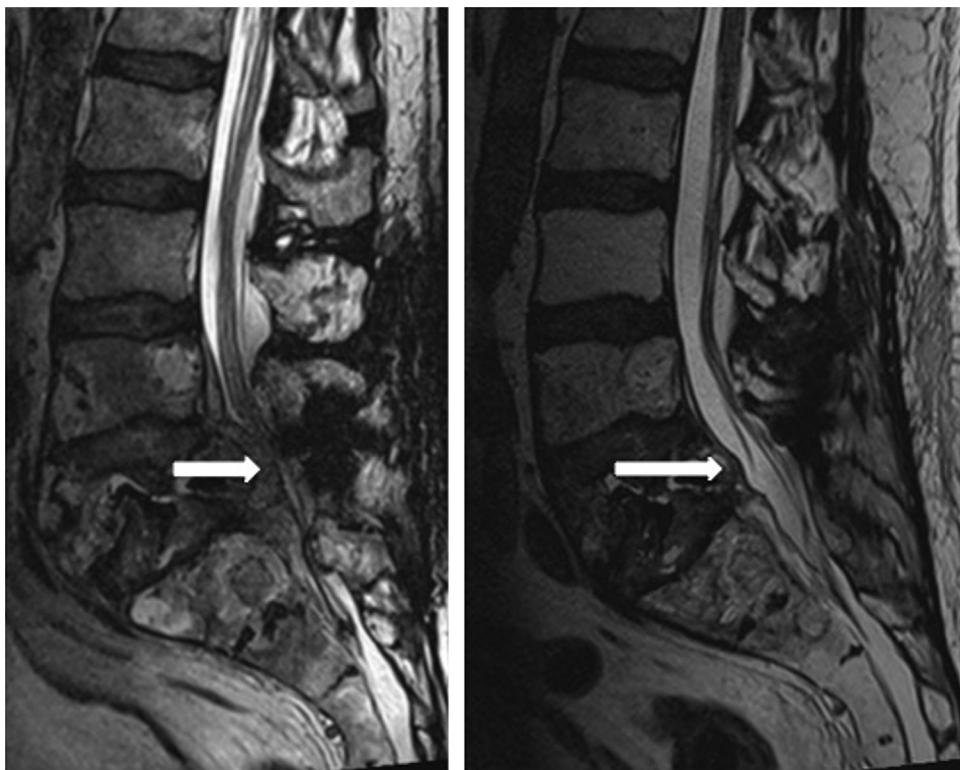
(Left) Sagittal T2-weighted images demonstrate the ventral epidural extension of tumor at L5 and S1 with severe central canal stenosis before radiation (arrow). (Right) Sagittal T2-weighted image 3 months after starting radiation therapy demonstrates significant improvement of epidural mass and resolution of central canal stenosis (arrow).
